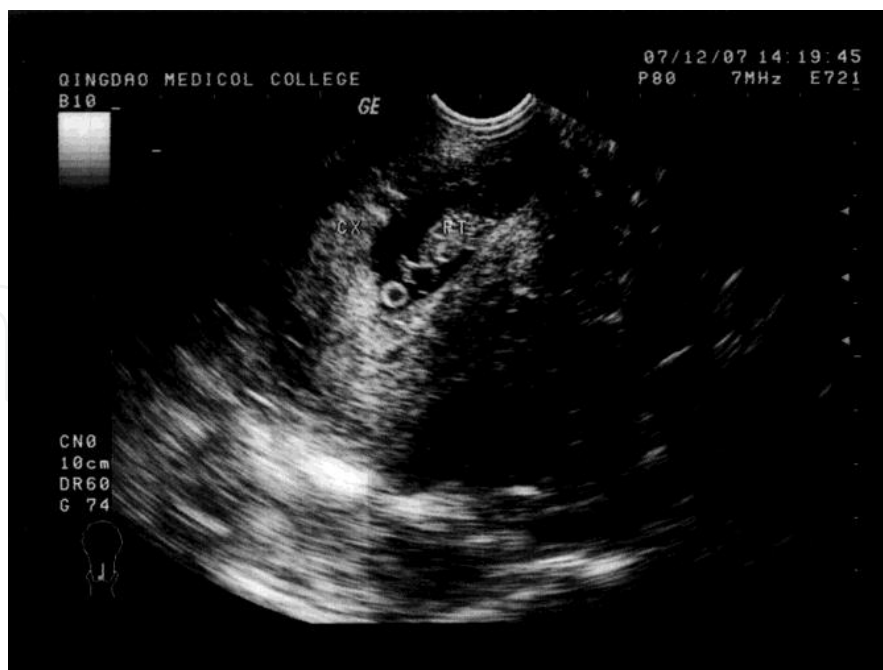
Tranvaginal ultrasound image of the cervical pregnancy. The same case as described in Figure 1. An enlarged cervix with a viable fetus in a gestational sac is evident under the closed internal os. CX: cervix; FT: fetus
